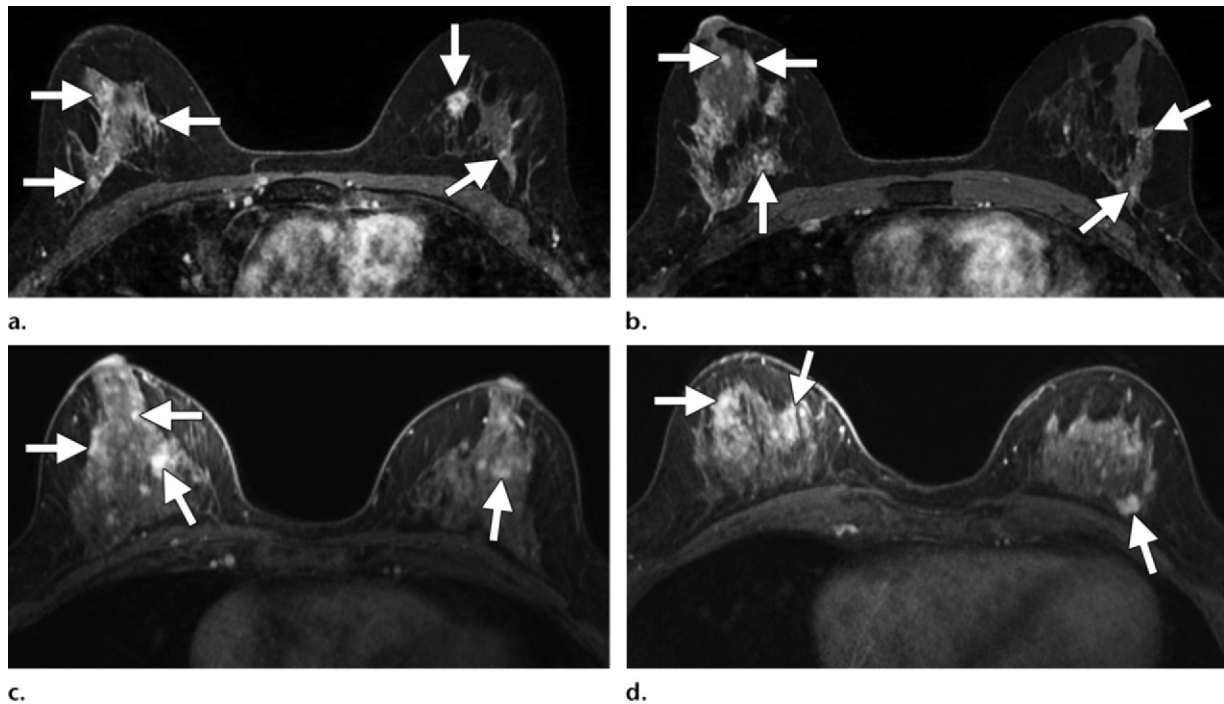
Moderate BPE with a distribution pattern of multiple foci and focal areas of enhancement in two different women. (a, b) Screening axial contrast-enhanced T1-weighted fat-suppressed MR images of a 49-year-old woman show multiple foci and larger focal areas of BPE (arrows), findings initially assessed as BI-RADS 3. Findings at follow-up imaging have been stable for more than 2 years. (c, d) Screening axial contrast-enhanced T1-weighted fat-suppressed MR images in a 49-year-old woman show multiple foci and focal areas of BPE (arrows). The findings were initially assessed as BI-RADS 3; findings at follow-up imaging have been stable to diminished for more than 2 years.
